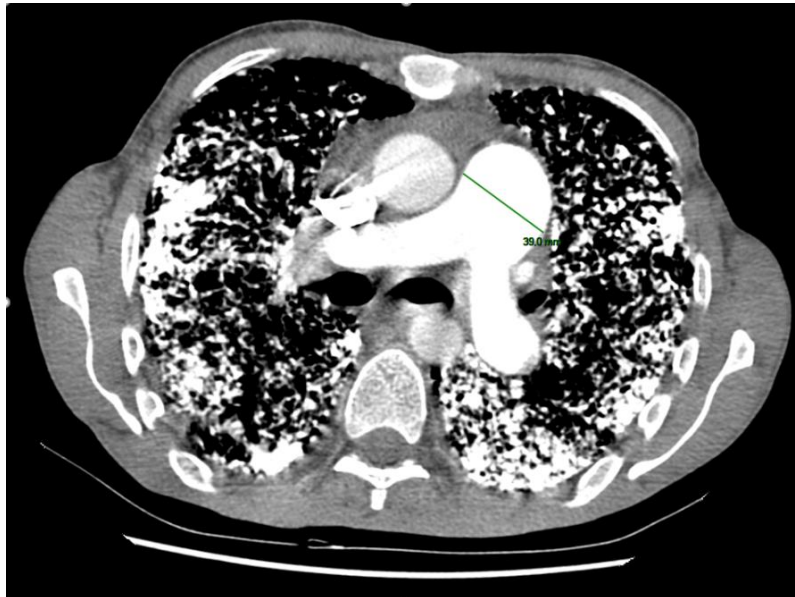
contrast-enhanced chest CT scan showing dilation of the main pulmonary artery
